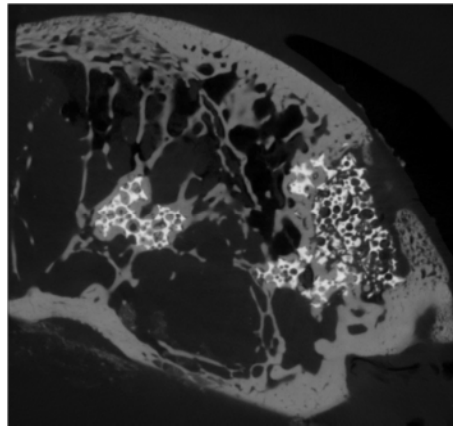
CT slice of 0.8 SA sample at 12 weeks.
